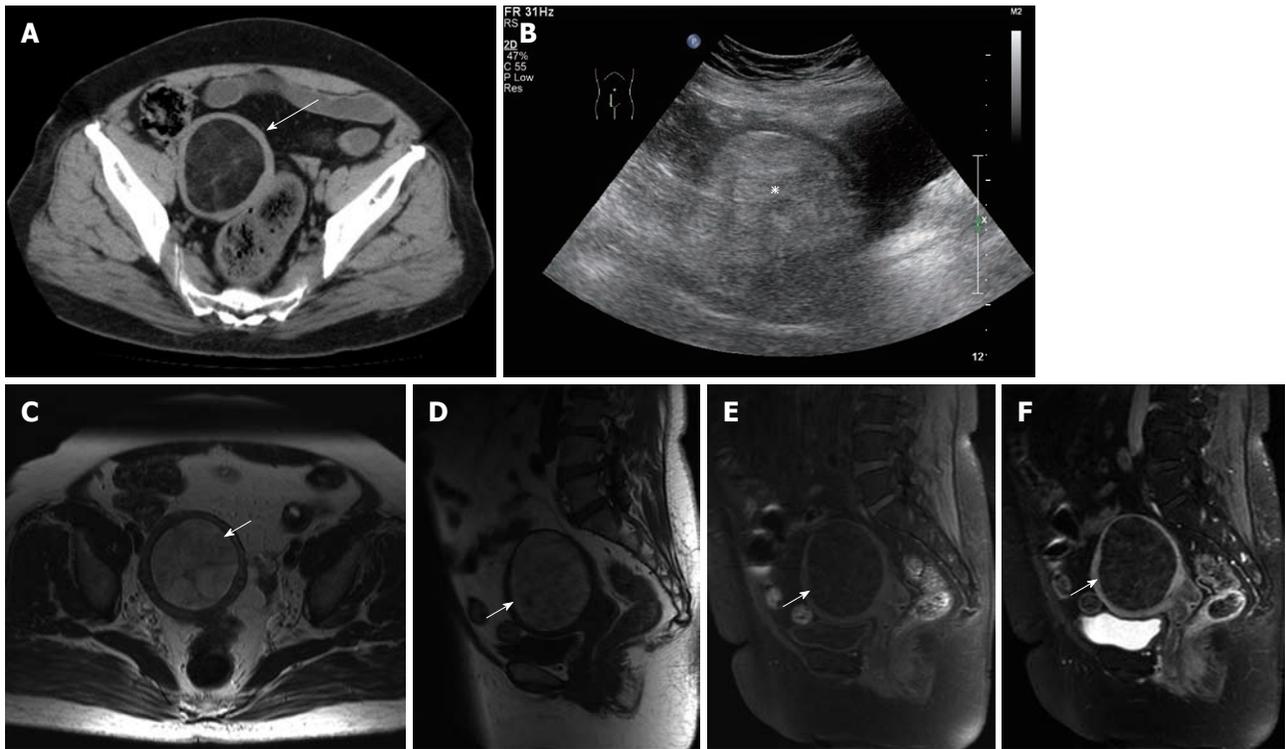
Computed tomography, ultrasound and magnetic resonance images of lipomatous uterine tumor in a 61-year-old woman. A: Computed tomography axial image of the pelvis with no contrast shows a hypodense lesion in the uterine fundus with thin internal septa (long arrow); B: Ultrasound in longitudinal view reveals a rather homogeneous and hyperechoic lesion (asterisk) in the uterus, just superior to the urinary bladder; C-F: Magnetic resonance imaging (MRI) images of the lesion. T1-weighted MRI images in axial plane (C) and in sagittal plane (D) show a T1 hyperintense lesion in the uterine fundus with thin hypointense septa (short arrows); E: Suppression of signal is seen in the T1-weighted fat-suppressed sequence, suggestive of fatty component of the lesion; F: Thin enhancing septa are seen inside the lesion after gadolinium contrast is administered.
